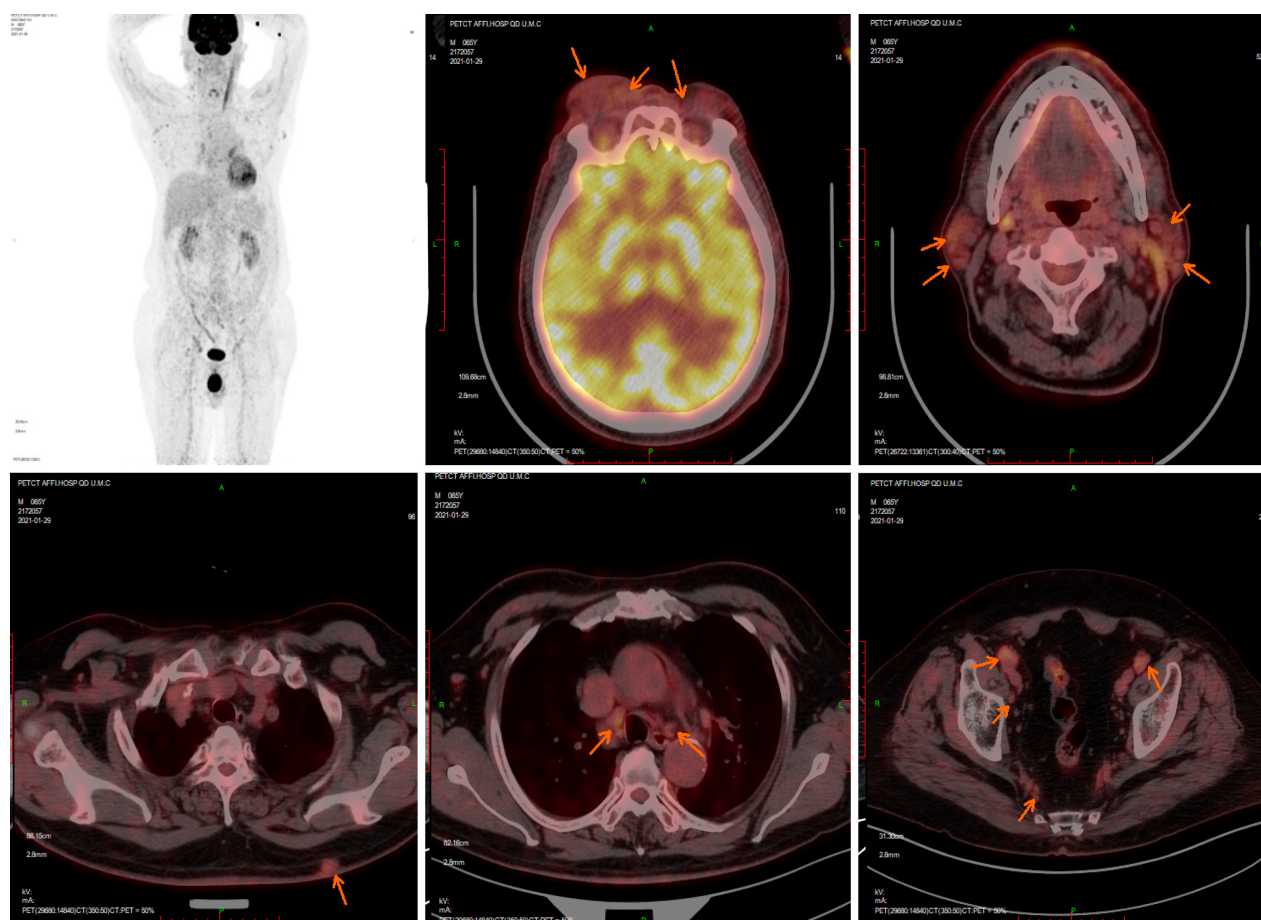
Positron emission tomography computed tomography on January 29, 2020. Positron emission tomography computed tomography revealed that bilateral ophthalmic muscles, lacrimal glands, intraorbital soft tissue, subcutaneous soft tissue nodules in the back, bilateral mediastinal pleura, and several superficial and deep lymph nodes all showed increased metabolism, accompanied by retroperitoneal fibrosis.
